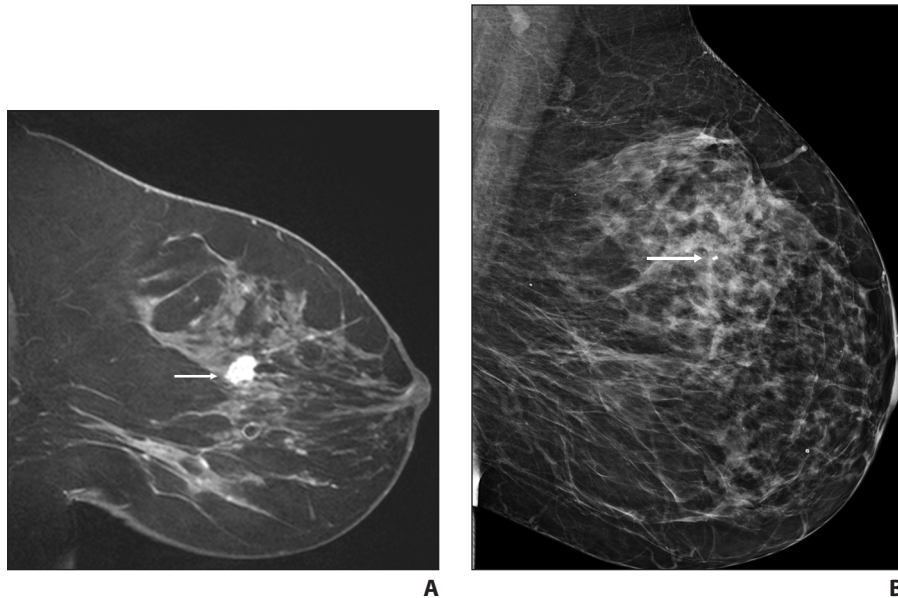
46-year-old woman with family history of breast cancer who underwent screening mammography and MRI. Asymptomatic breast cancer was detected on MRI but not on mammography. A, Sagittal contrast-enhanced subtraction MRI shows irregular, enhancing mass (arrow) in left breast, with subsequent biopsy revealing invasive lobular carcinoma. B, Left mediolateral oblique mammogram performed after biopsy shows biopsy clip (arrow) denoting location of cancer. No mammographic evidence of malignancy is seen at site of biopsy clip.
